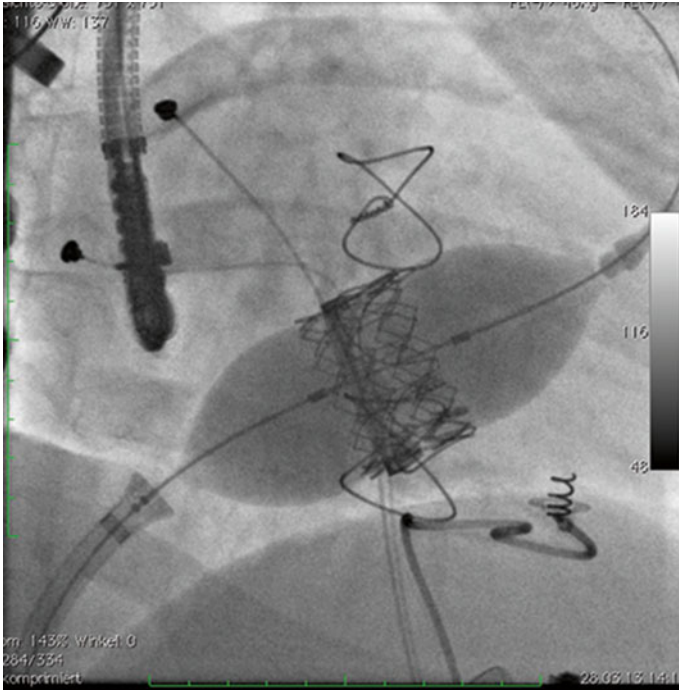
An Edwards Sapien XT 29 mm valve is positioned within a 31 mm Perimount prosthesis under fluoroscopic and TEE guidance. The anterior posterior x-ray plane was rotated to completely perpendicular level, and only the last proximal struts of the Sapien valve “peak” out of the bioprosthesis. This position enables optimal valve function and prevents valve embolization into the ventricle. The patient was an 18-year-old girl after three open heart surgeries and two additional pacemaker implantations who presented with severe regurgitation of the Perimount valve
